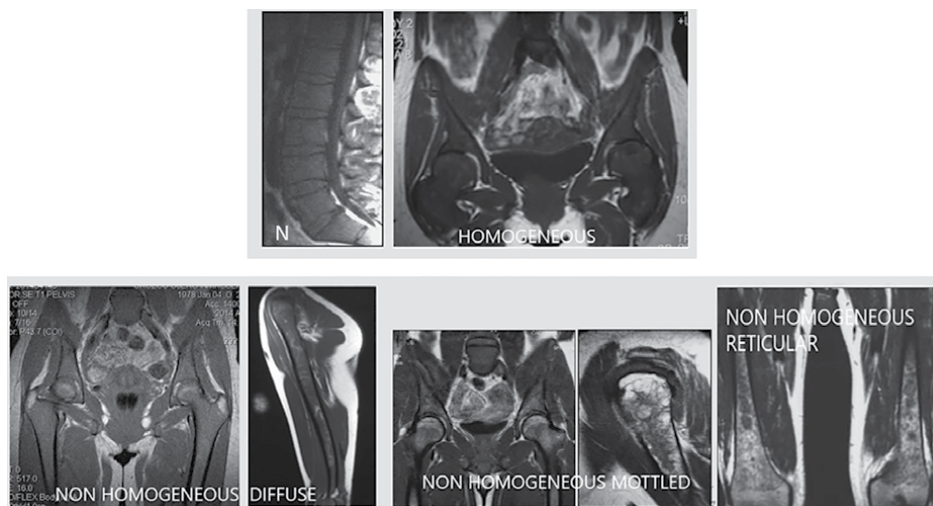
Bone marrow infiltration. MRI patterns described by Roca-Espiau et al. 2007. Three MRI patterns were defined: Normal, homogeneous, and nonhomogeneous infiltration subtypes reticular, mottled, and diffuse.
